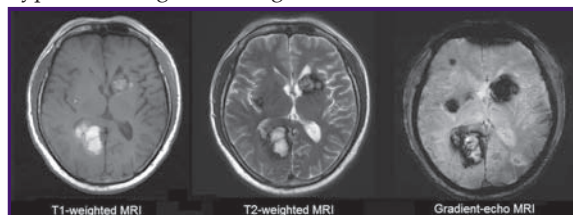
Cavernous haemangioma appears in T1, T2 and gradient-echo MRI.
